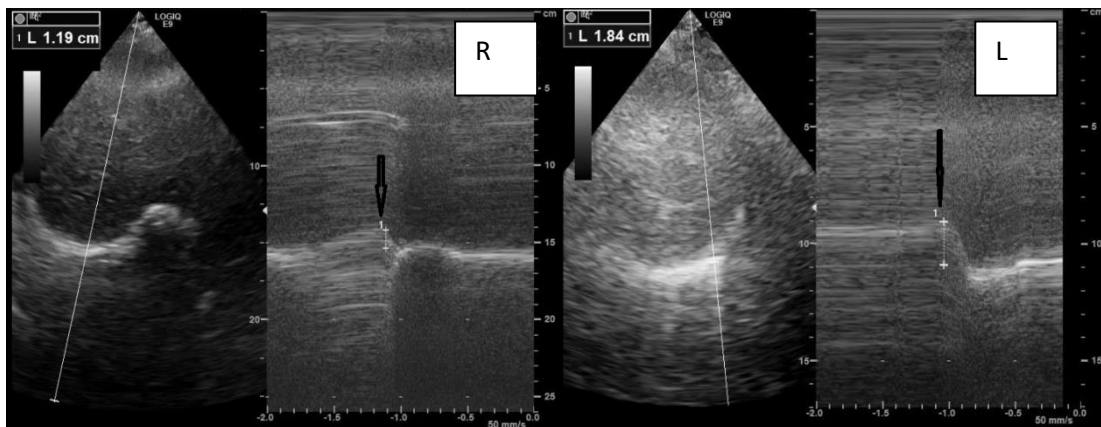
and figure 2: Right and left hemi diaphragm paradoxical displacement using M mode ultrasound during a sniff maneuver.
